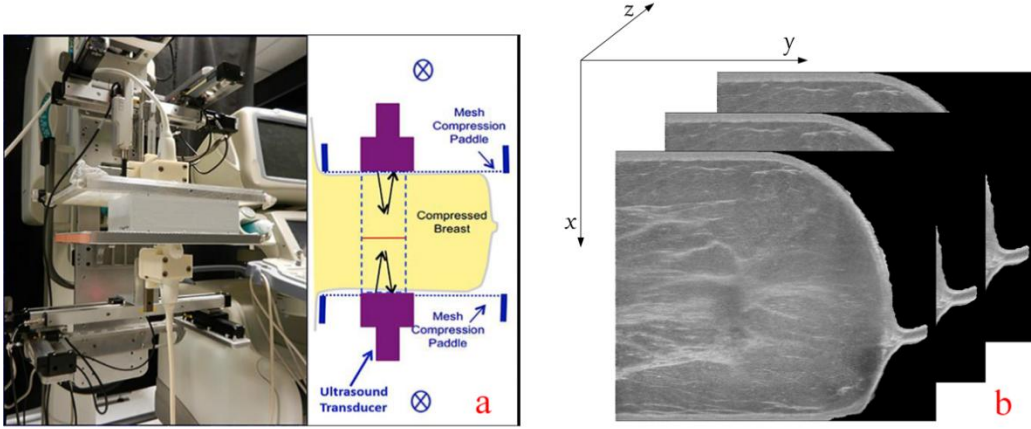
(a) The BLUCI system; (b) 2D breast ultrasound image sequence
